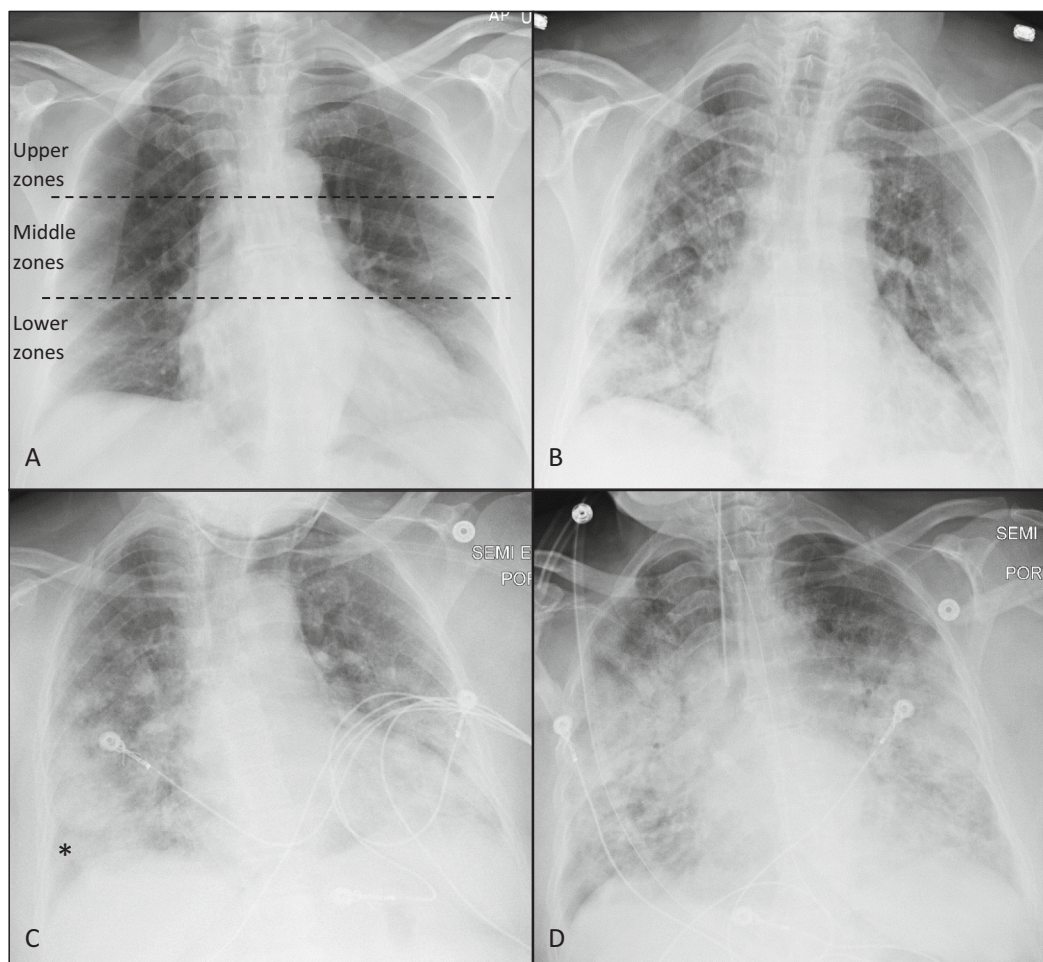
AP chest radiographs of a 65 years-old female presented with moderate symptoms. Hypertension was the only co-morbidity. Both observers assigned CoV-P1 category to the baseline CXR with GGO involving bilateral lower zones (A). GGO became more extensive 2 days later (B) with CoV-P2 category assigned by both observers (4 and 5 zones were considered involved by each observer) with increased consolidation component. There was no significant change in clinical status other than improvement of shortness of breath reported by the patient at the time of this CXR. Patient deteriorated clinically on the third day with severe symptoms and was transferred to the intensive care unit. CXR on the fourth day (C) shows more extensive involvement with increased consolidation noted mainly peripherally (*). Patient was intubated 6 days after admission (critically severe) and developed ARDS features (D).
